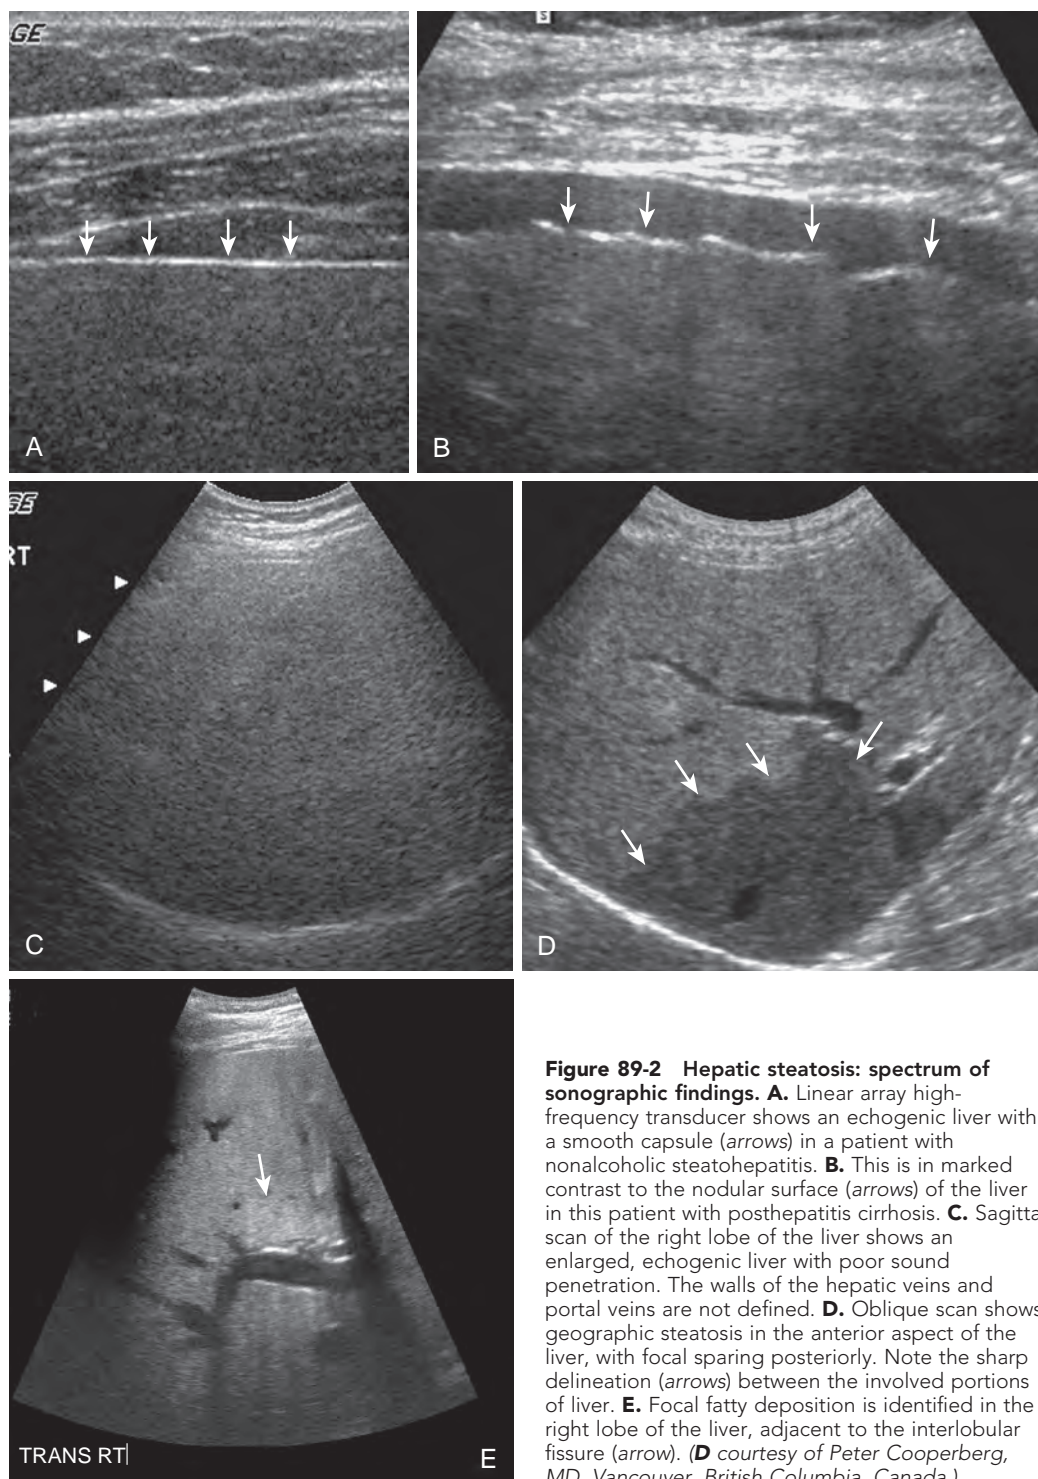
Hepatic steatosis: spectrum of sonographic findings. A. Linear array high-frequency transducer shows an echogenic liver with a smooth capsule (arrows) in a patient with nonalcoholic steatohepatitis. B. This is in marked contrast to the nodular surface (arrows) of the liver in this patient with posthepatitis cirrhosis. C. Sagittal scan of the right lobe of the liver shows an enlarged, echogenic liver with poor sound penetration. The walls of the hepatic veins and portal veins are not defined. D. Oblique scan shows geographic steatosis in the anterior aspect of the liver, with focal sparing posteriorly. Note the sharp delineation (arrows) between the involved portions of liver. E. Focal fatty deposition is identified in the right lobe of the liver, adjacent to the interlobular fissure (arrow). (*D* courtesy of Peter Cooperberg, MD, Vancouver, British Columbia, Canada.)
